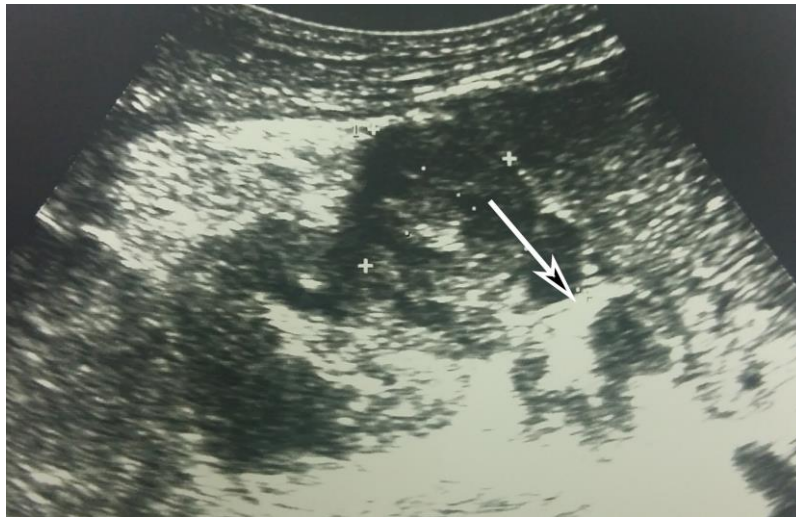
Ultrasound depicts target sign (arrow head)
